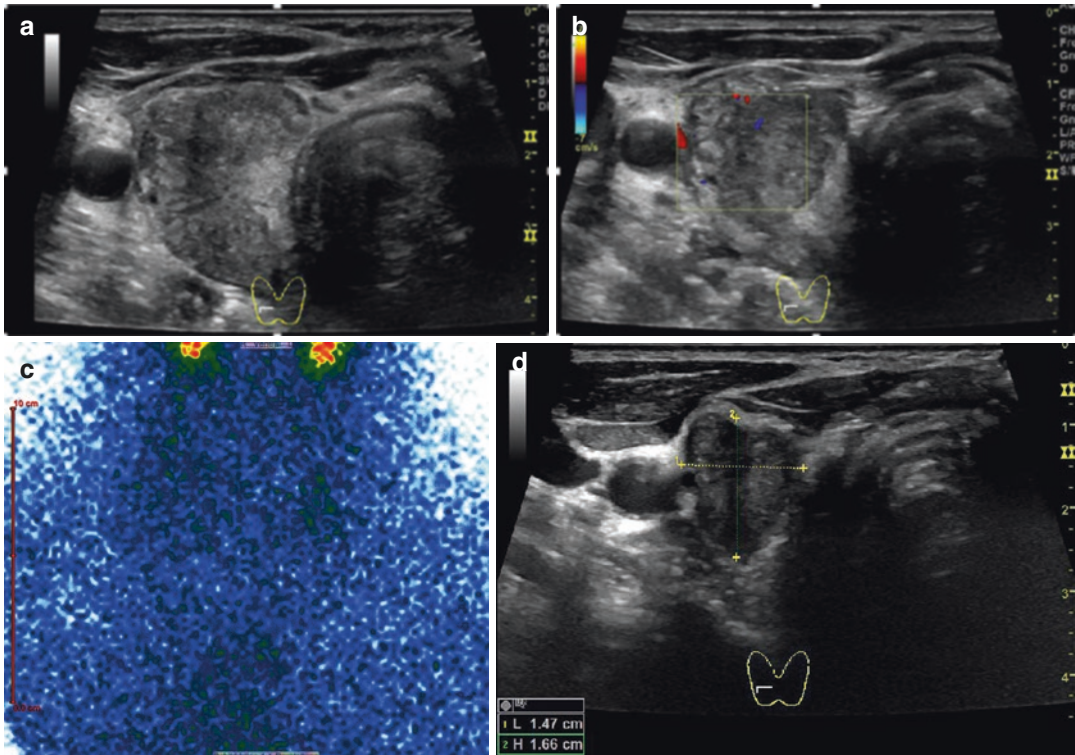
(a–d) Seventy-three-year-old male patient presenting with neck pain. TSH 0.01 mU/L, free T3 and free T4 normal, thyroid antibodies not elevated. (a) B-mode ultrasound (right thyroid lobe, transverse image) showing thyroid gland enlargement (volume right lobe: 17 mL, left lobe: 12 mL) and confluent hypoechoic areas in both
